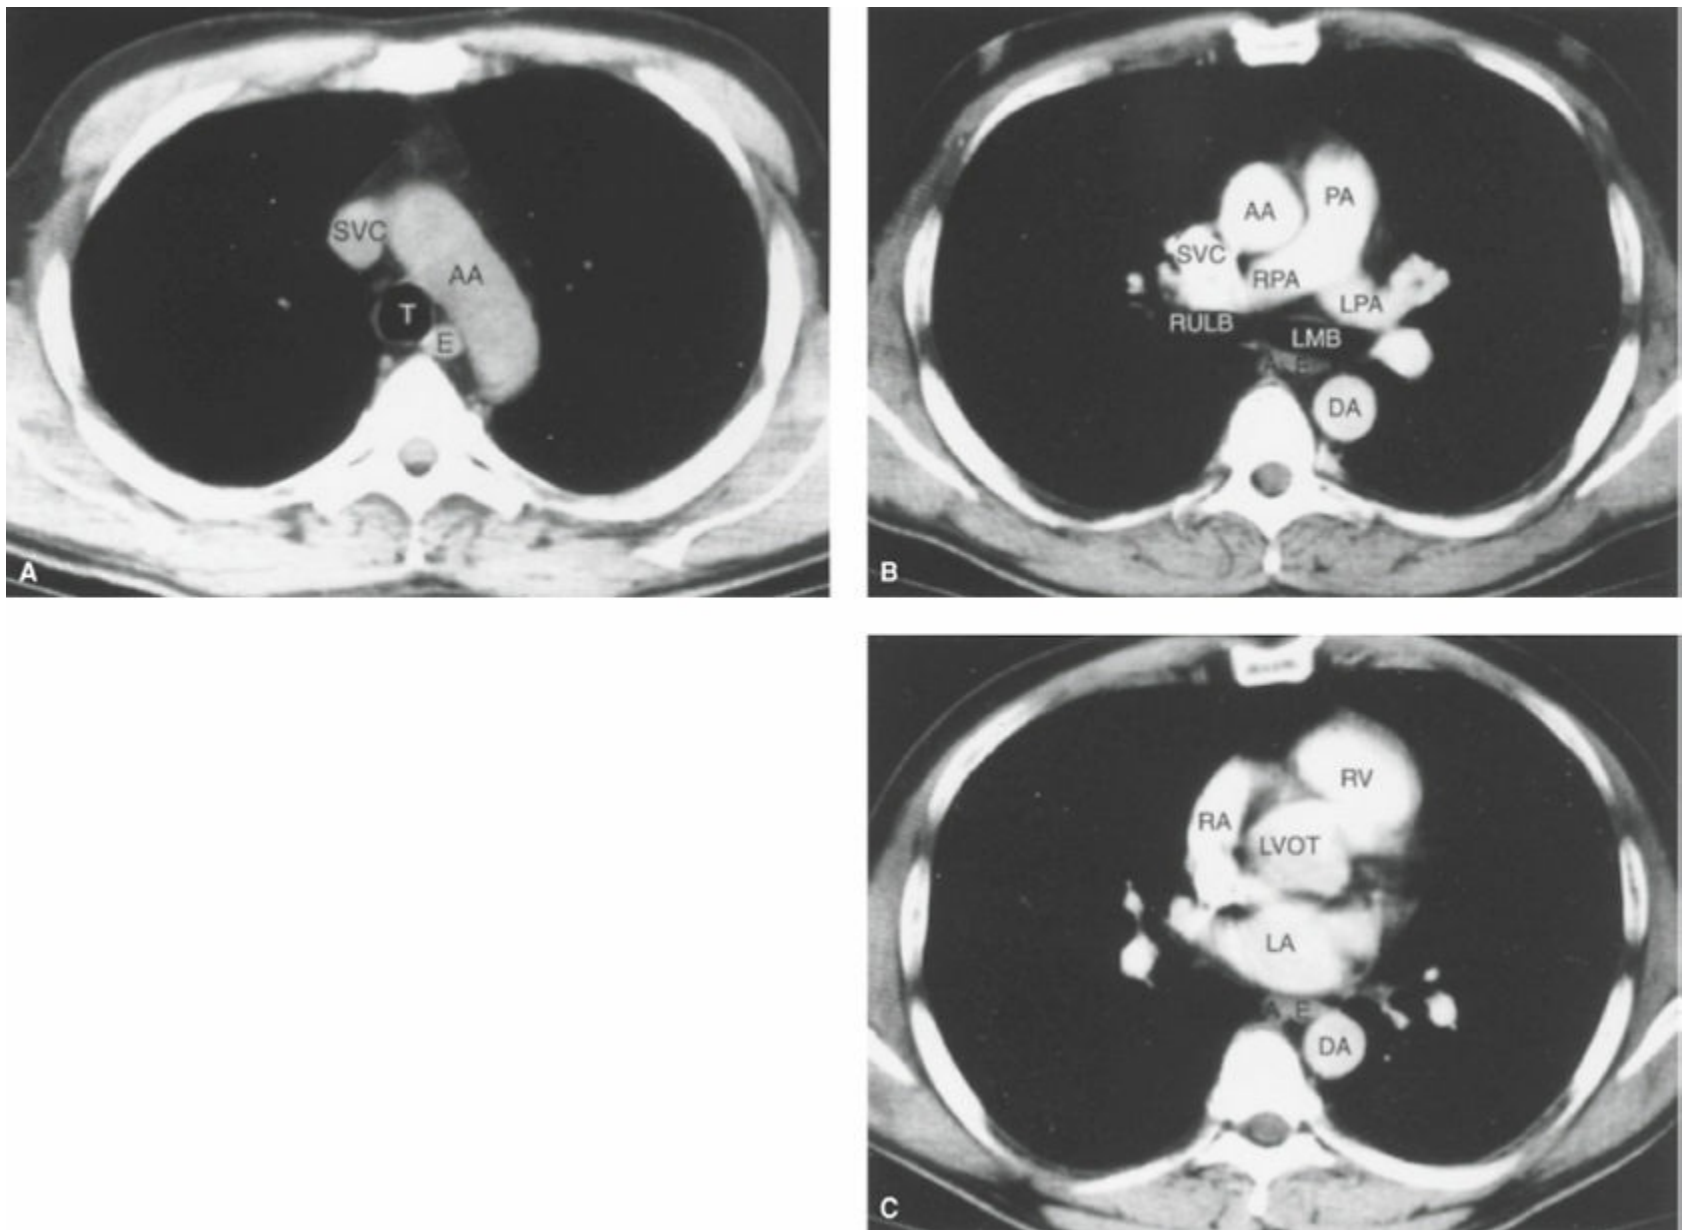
Normal mediastinal anatomy as shown with computed tomography scans. A: Scan at level of the aortic arch and midtrachea. T, trachea; E, esophagus; AA, aortic arch; SVC, superior vena cava. B: Scan at level of carina. RULB, right upper-lobe bronchus; LMB, left mainstem bronchus; AA, ascending aorta; DA, descending aorta; A, azygos vein; PA, main pulmonary artery; LPA and RPA, left and right pulmonary arteries. C: Scan at the level of the left atrium. LA, left atrium; RA, right atrium; LVOT, left ventricular outflow tract; RV, right ventricle.
